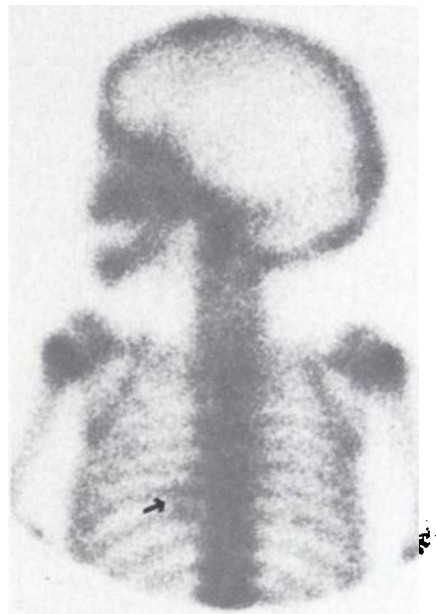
Posterior bone scintigram demonstrating abnormal soft-tissue activity in left paraspinal region (arrow), with normal uptake by adjacent bony structures.
